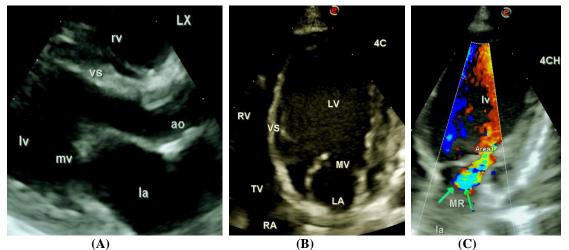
Mitral regulation. (A) In the parasternal LX and (B) apical 4CH views anterior and posterior mitral valve leaflets were elongated and markedly thickened; (C) Mild mitral regurgitation jet was delineated with a jet area of 0.62 sqcm.
